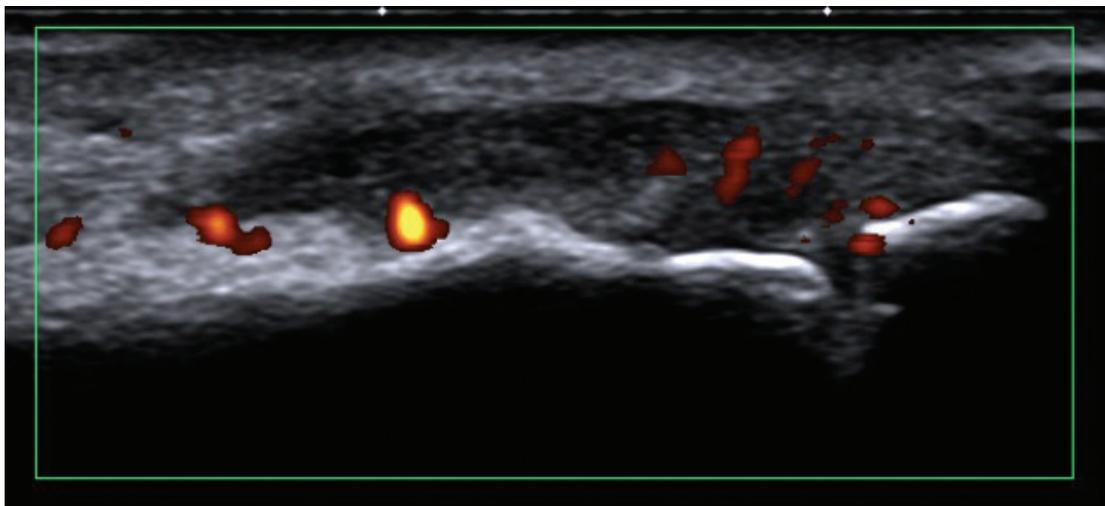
Ultrasound: synovitis in the PIP (proximal interphalangeal) 2 joint
